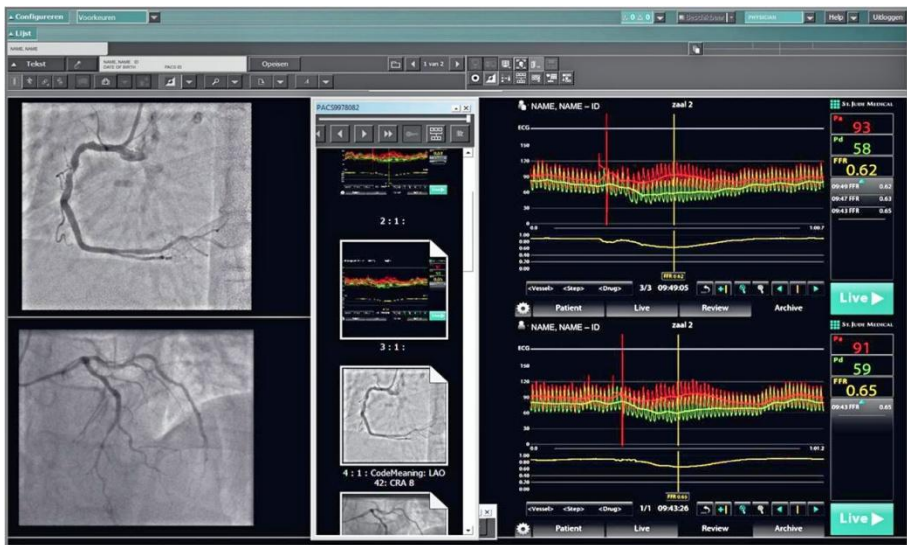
Fractional Flow Reserve: example of simultaneous DICOM format storage of complete physiological and angiographic information. Archiving this information (as well as intravascular ultrasound and optical coherence tomography, when available) side-by-side, in a format that is easily accessible (“same place, same time” principle) enables surgeons, interventional cardiologists, clinicians, and heart team meeting participants to be exposed to these different imaging modalities and to integrate “anatomy” and “physiology” into individual clinical decision making. CRA: cranial; DICOM: digital imaging and communications
